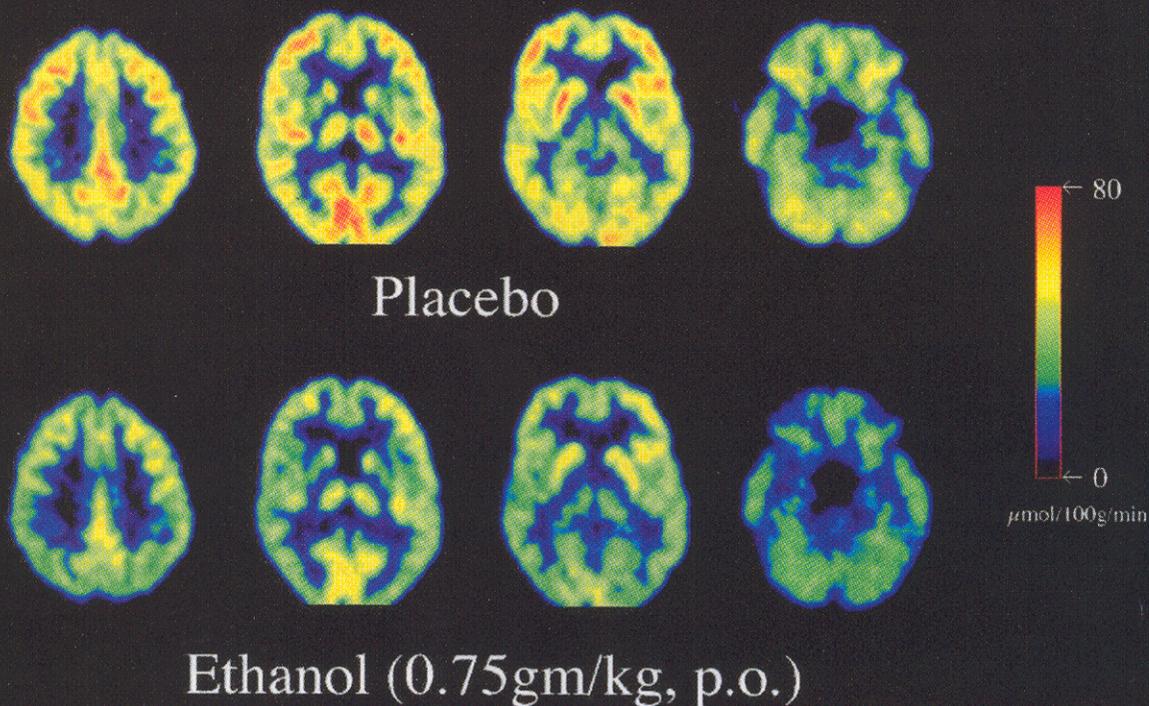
FDG-PET images of normal subject after placebo (diet soda) and ethanol (0.75 g/kg).
